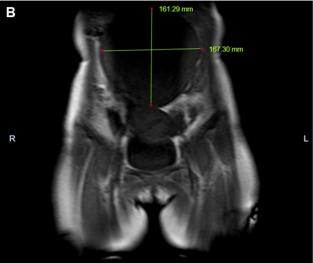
CT image of the pelvic mass before initial open abdominal surgery in sagittal view (A) and coronal view (B).
